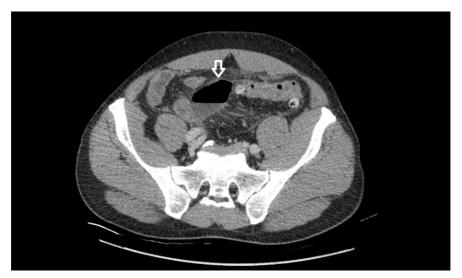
A large abscess (arrow) in the CT image of complicated acute diverticulitis.
